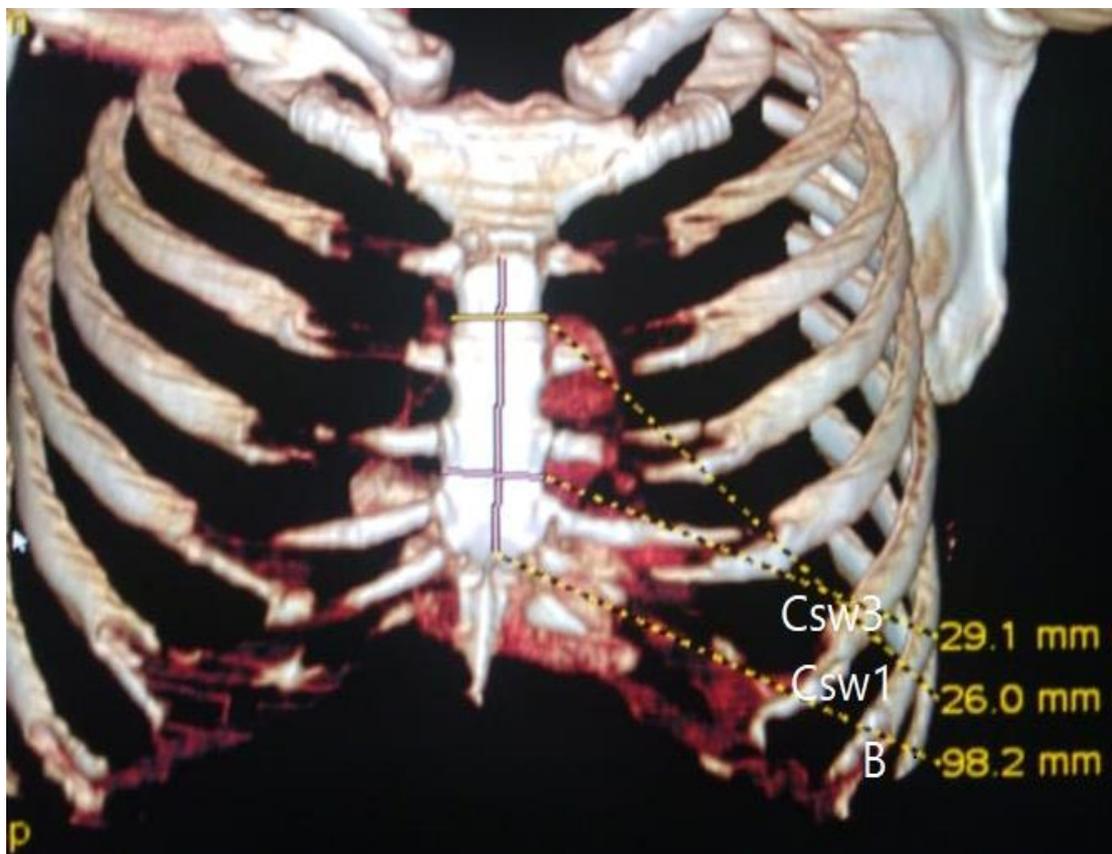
Computed tomography imaging showing sternal body length and width of sternum at 1st and 3rd sternal depression in one of the male participants; (B) sternal body length; (Csw1) width of sternum at 1st sternal depression; (Csw3) width of sternum at 3rd sternal depression.
